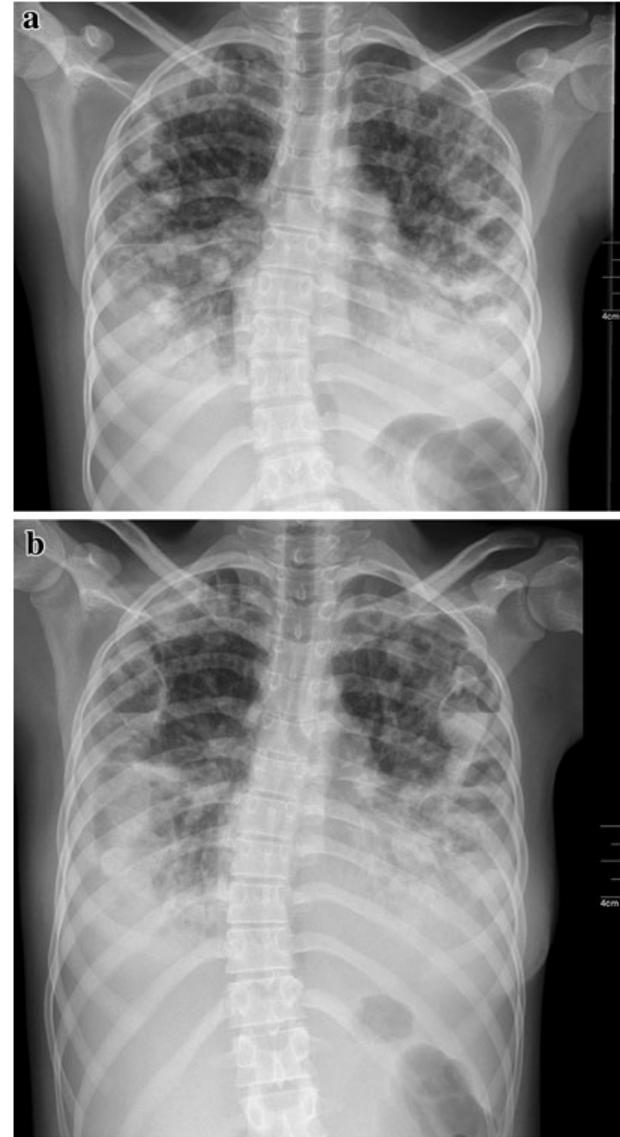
a Chest X-ray at admission shows bilateral infiltrates and cavitary lesions. b Chest X-ray 6 days after admission demonstrates deterioration of cavitary lesions with air-fluid levels
